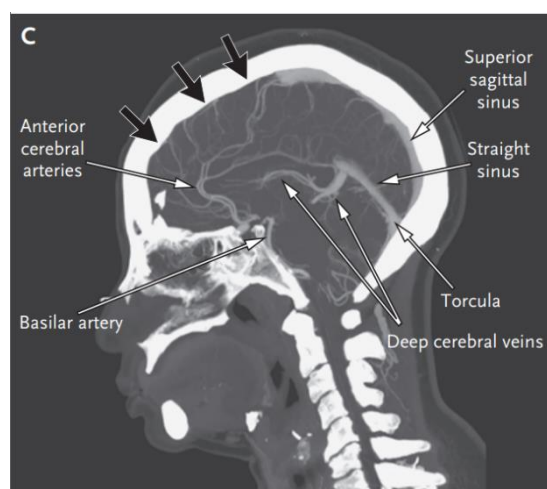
Can axial image from CT of the Head (Panel A).
